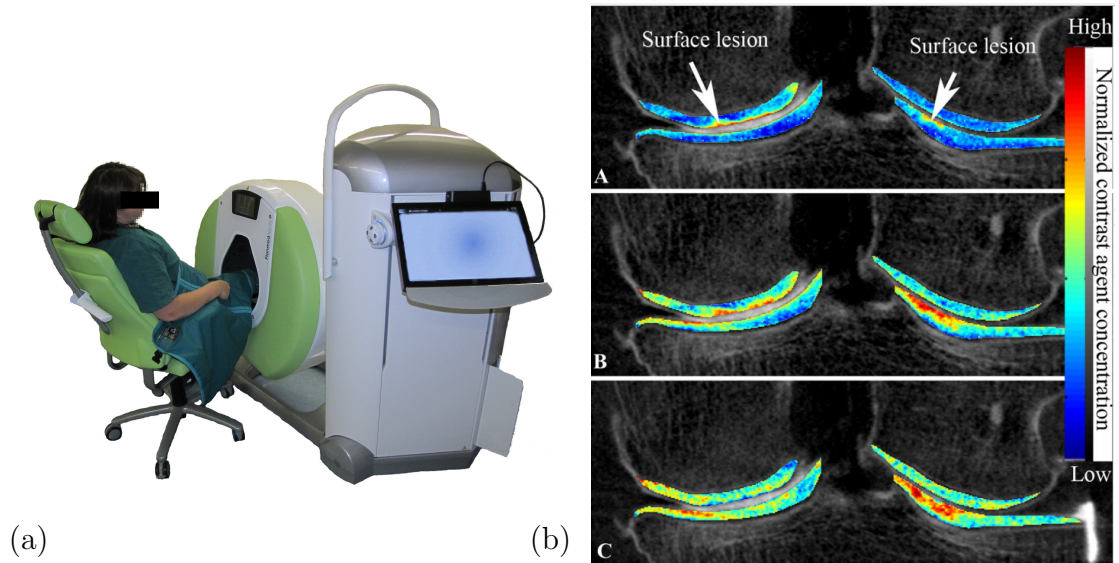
(a) A modern peripheral CBCT scanner (Verity, Planmed Oy, Helsinki) optimized for orthopedic imaging. (b) (A) Arthrographic images are acquired immediately after the contrast agent injection highlighting the cartilage lesions. (B) Delayed images acquired 45 minutes after the contrast agent injection, in addition to cartilage lesions, highlighting also inferior cartilage integrity around the original lesion. (C) Images depicting difference between the delayed and arthrographic images (i.e. contrast agent diffusion). Detecting initiation of PTAO is possible based on these images. [37]
